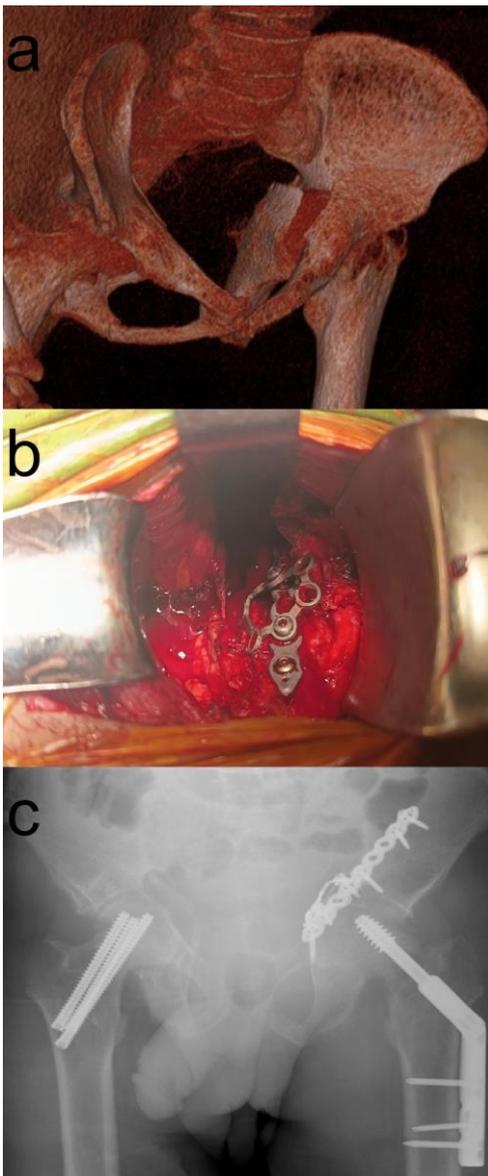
(a) Preoperative 3D computed tomography (CT) imaging of an 18-year-old male patient with a left acetabular fracture, quadrilateral plate fracture, and bilateral femoral neck fractures. (b) Intraoperative image of a contoured titanium locking calcaneus plate attached to a suprapectineal reconstruction plate via a modified Stoppa approach. (c) Radiograph at the one-year follow-up.
